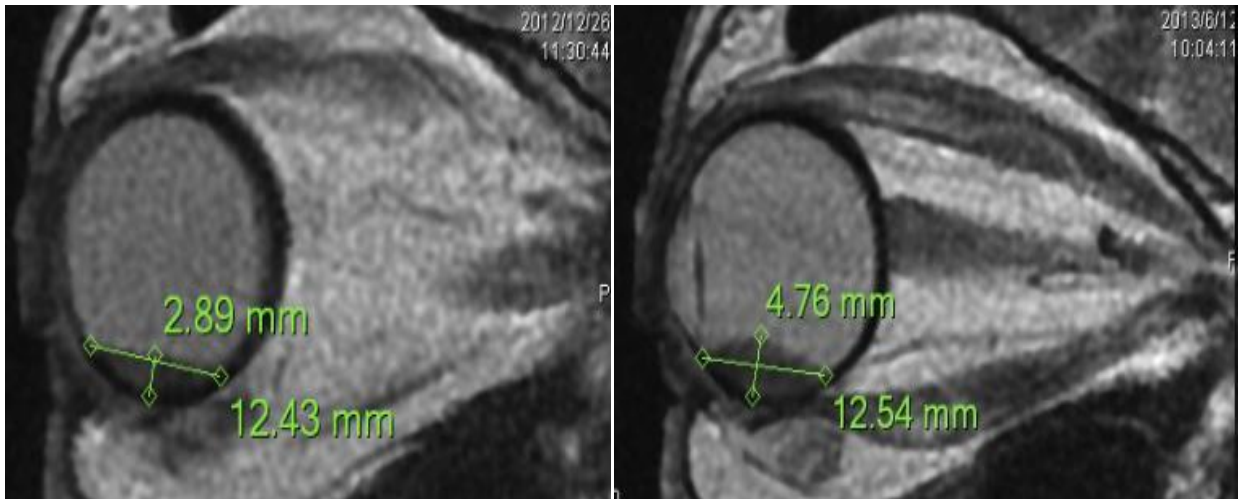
Local Recurrence. Sagittal MR imaging and USG imaging of patient 36th month post radiotherapy.
